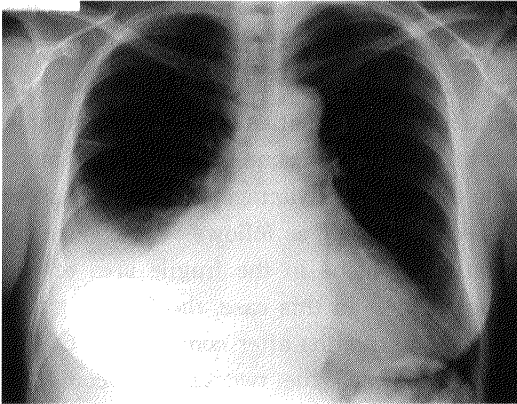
Chest radiograph on admission showing massive right-sided pleural effusion.
